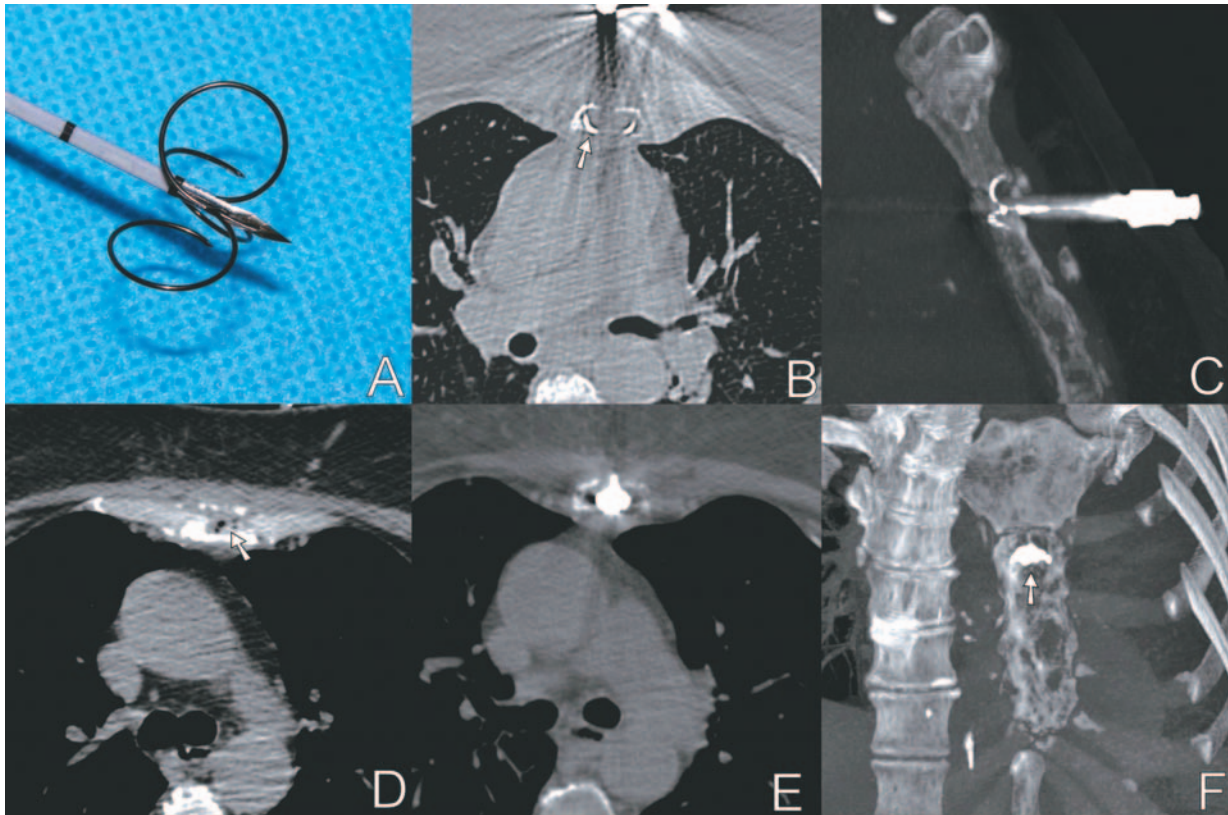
A) RF needle with partially deployed tines. B) RF needle positioning using CT control. Only tines are visible (arrow). C) MIP reconstruction: RF needle with deployed tines positioned in the lesion. D) Gas bubbles (arrow) in the upper side of the lesion some minutes after the RFTA procedure. E) Polymethylmethacrylate (PMMA) introduction after RFTA. F) MIP reconstruction: PMMA distribution in the lesion at the end of the procedure.
